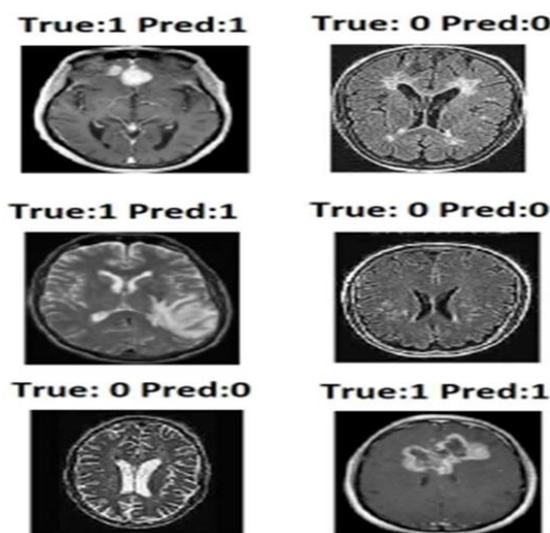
Accurately and inaccurately predicted MRI images
